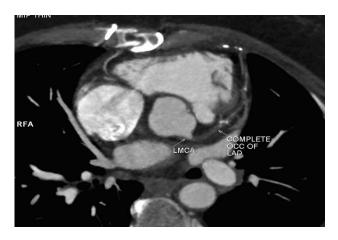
CT image of native vessel evaluation showing complete occlusion of proximal LAD.
